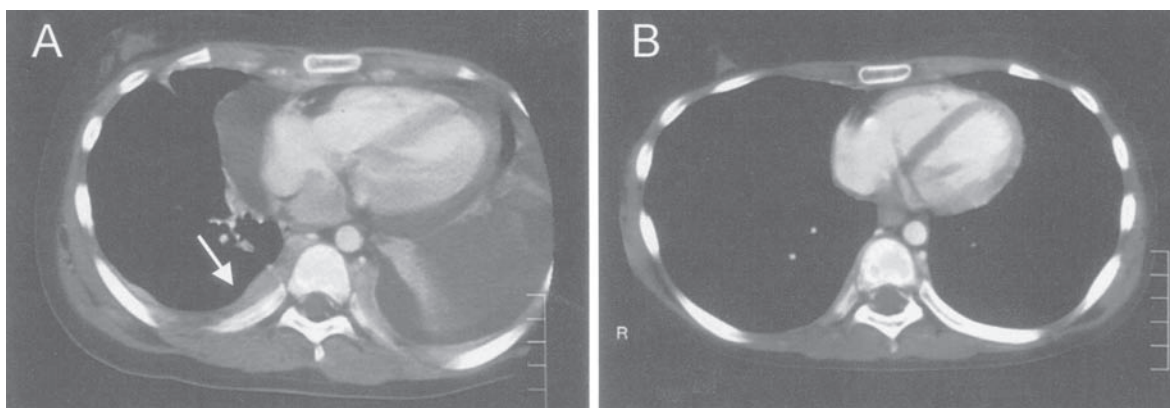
Computed tomography images of the chest at relapse (a) and 48 days after relapse (b). The arrow indicates the pleural infiltration of the lymphoma.
